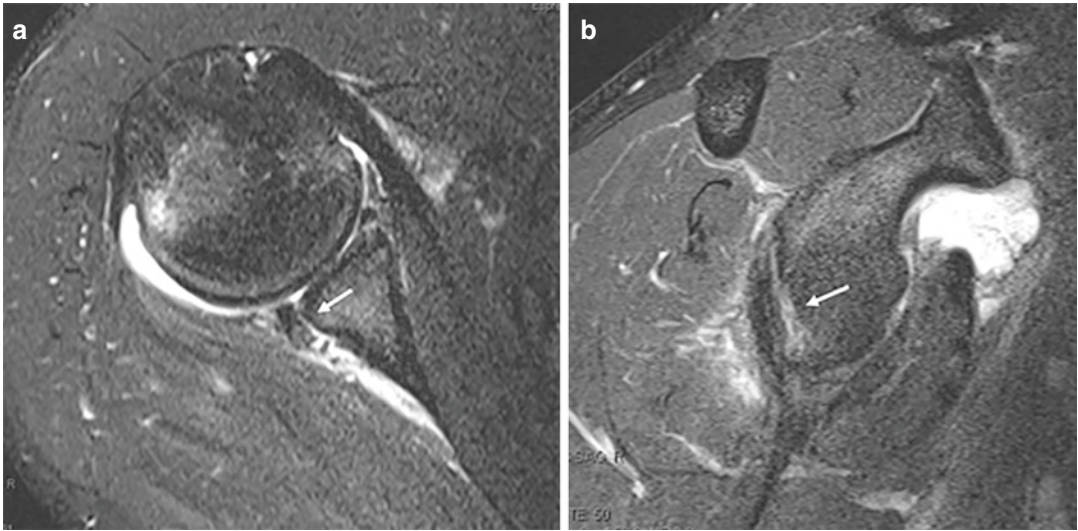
Magnetic Resonance Imaging (MRI) of a left shoulder with a posterior labral tear. Image (a) is a T2-weighted axial MRI demonstrating a posterior labral
